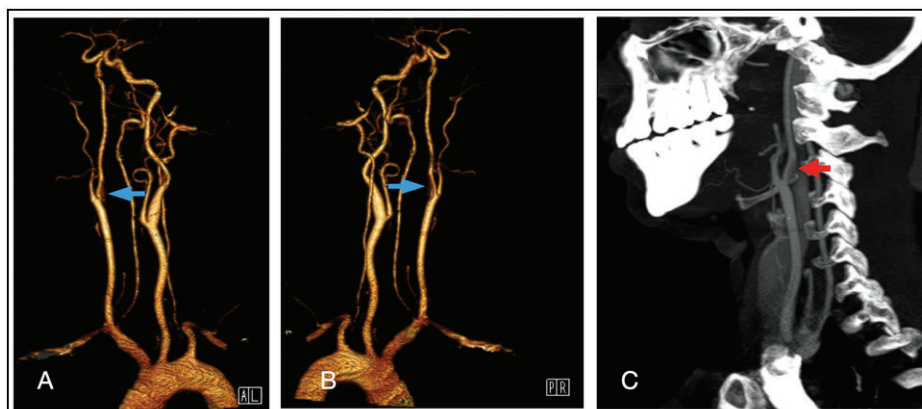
CT Angiography showing right internal carotid dissection at its origin (A-C)
